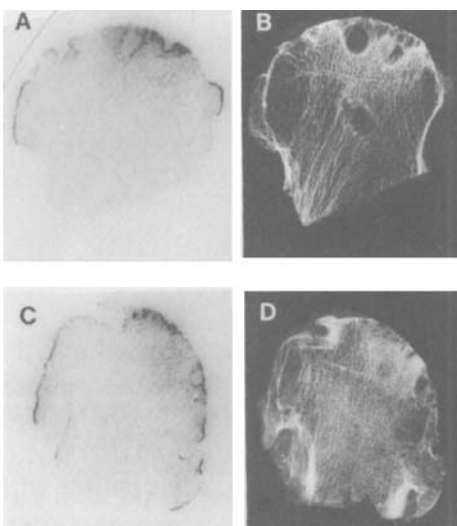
Autoradiographs of hemisections and roentgenographs of thin slices of osteoarthritic femoral heads from two patients, one given $^{99\text{m}}\text{Tc}$ -polyphosphate (Fig. 15, A) and the other $^{99\text{m}}\text{Tc}$ -methylene diphosphonate (Fig. 15, C) preoperatively.
